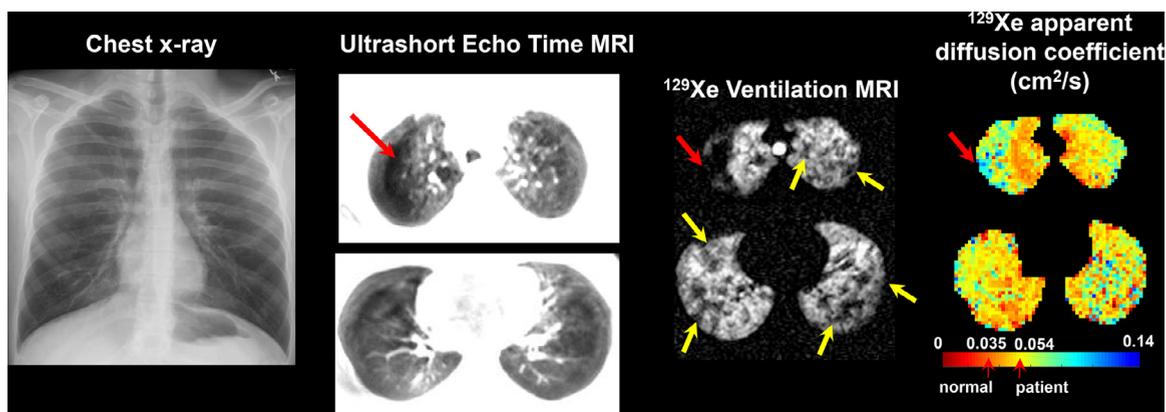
Patient's chest X-ray study showing hyperinflation but otherwise no remarkable signs of lung pathologies. Axial slices of proton ultrashort echo time, ¹²⁹Xe ventilation, and ¹²⁹Xe apparent diffusion coefficient images, from left to right, demonstrating a small bullous area in the apex (red arrow), widespread focal ventilation defects (yellow arrows), and near-uniformly elevated apparent diffusion coefficient (0.054 cm²/s) indicative of enlarged alveolar airspaces.
